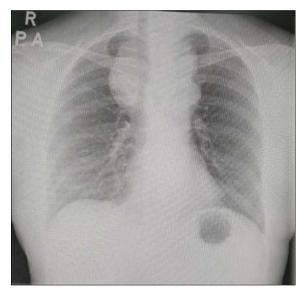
Chest radiograph: A well-defined homogeneous opacity in anterior mediastinum with cervicothoracic sign that projected above both clavicles. Trachea is deviated to right
